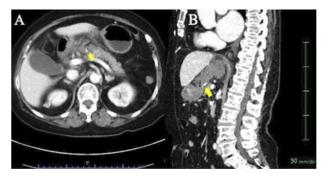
Abdominal CT shows a linear high-intensity structure (arrow) that penetrates the posterior wall of the antrum of the stomach outside the stomach wall (A: cross section, B: sagittal section).
